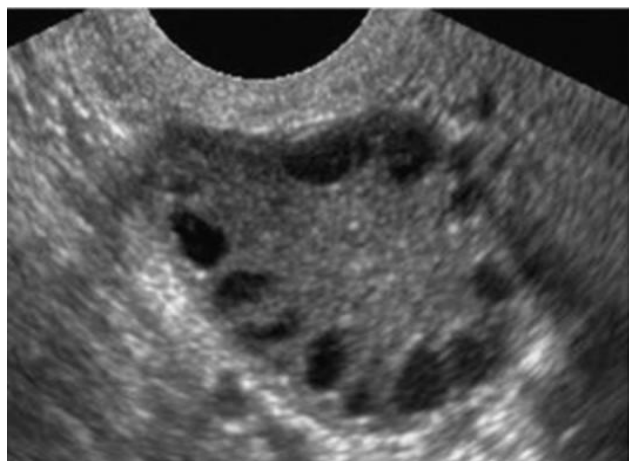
Ultrasound picture of polycystic ovary.
